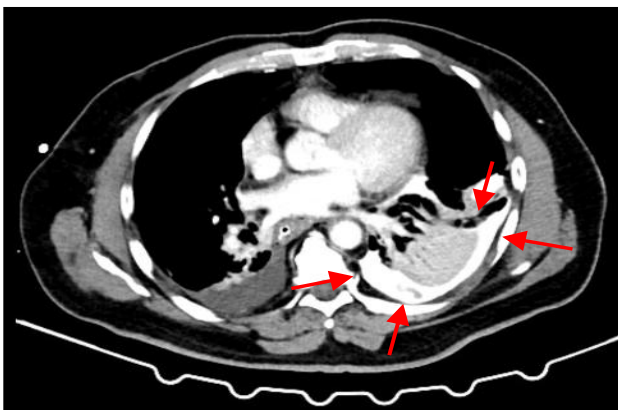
CT scan showing contrast extravasation in the mediastinum indicative of lower esophageal perforation (Red arrows).
